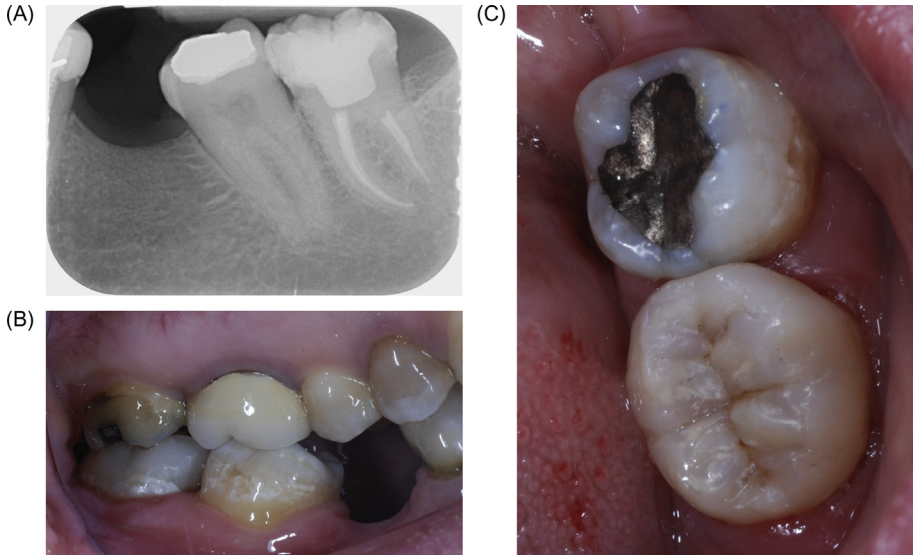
Post-operative situation: (A) radiograph; (B) lateral view; (C) occlusal view.
